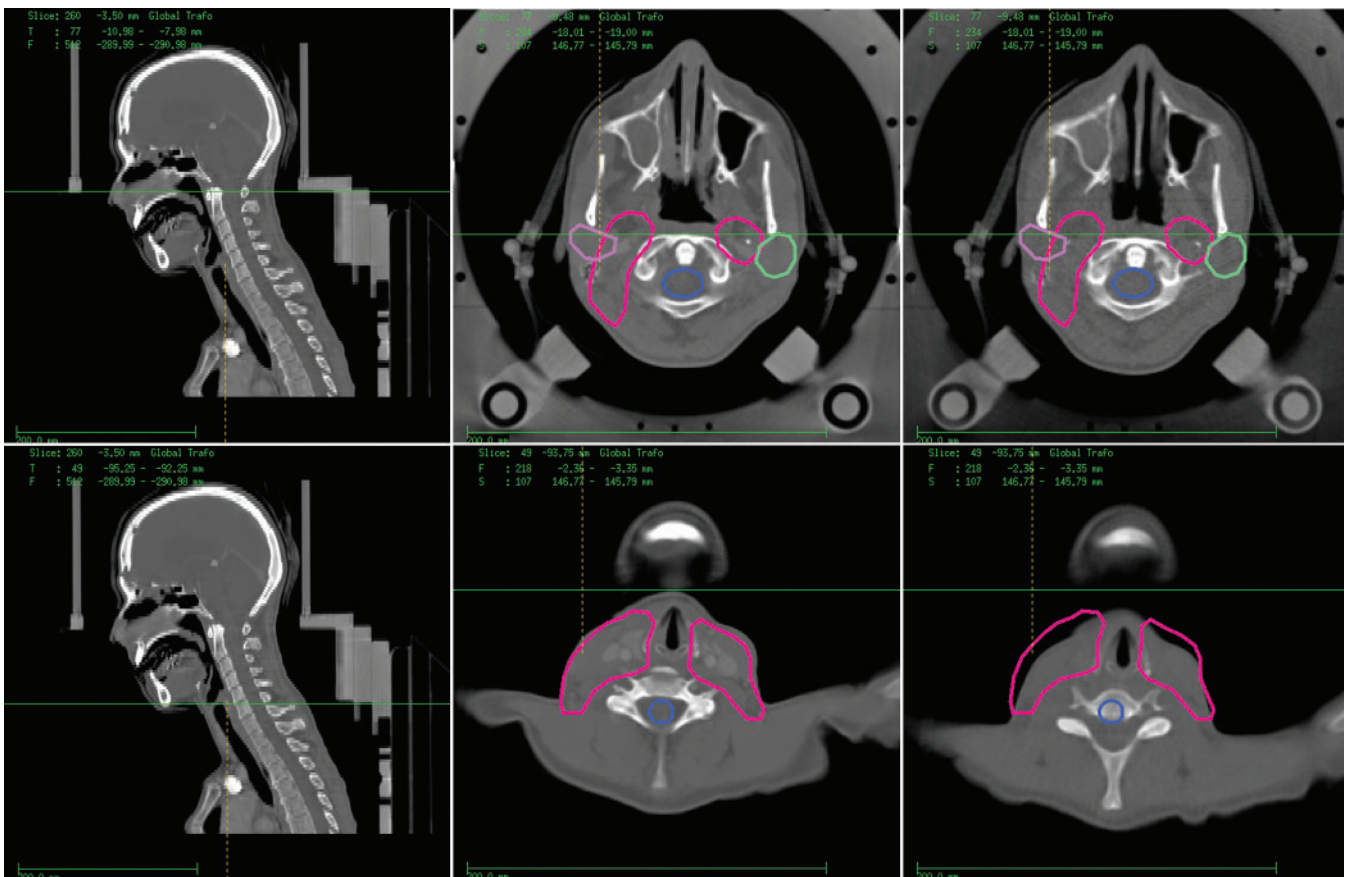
Exemplary head and neck case – comparison of planning CT and control CT at fraction 20. In the first row the good repositioning in the upper part of the target can be seen, and the second row shows the error of approximately 1.5 cm along the y-axis in the lower part of the target volume.
